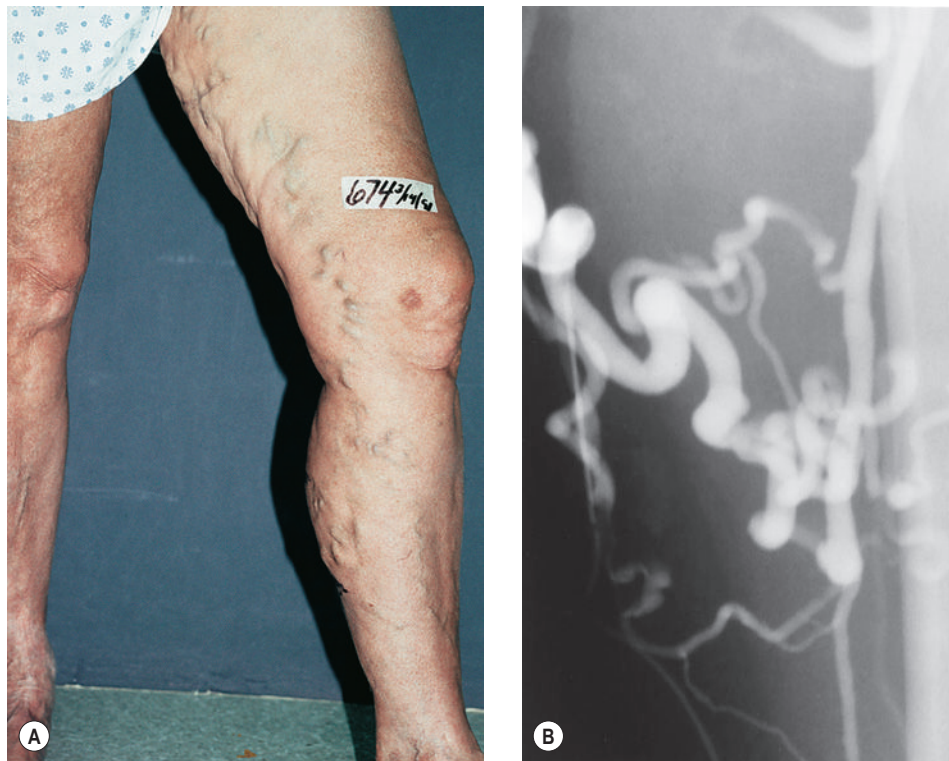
A, This patient presented with a recurrent varicosity 25 years after great saphenous vein (GSV) stripping. Duplex ultrasound showed no reflux at the level of the saphenofemoral junction and no evidence of a GSV but was unable to demonstrate the connection of the varicosity to the deep venous system. B, Varicography clearly showed the proximal site of connection as well as sites of additional incompetent perforating veins.
